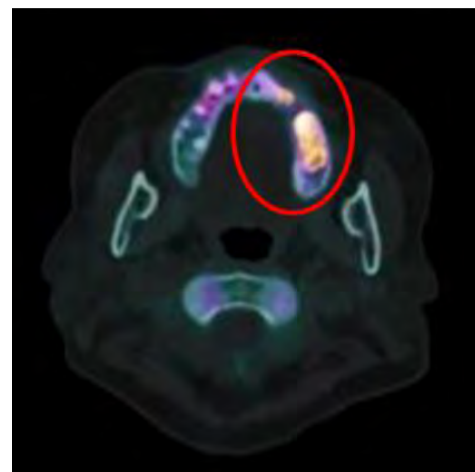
On postoperative day 8 months, the radiological assessment of the surgical site was conducted through Bone SPECT CT imaging. The results revealed decreased intensity at the surgical site, accompanied by gross residual uptake in a known bone lesion located at the maxillary alveolar process.
